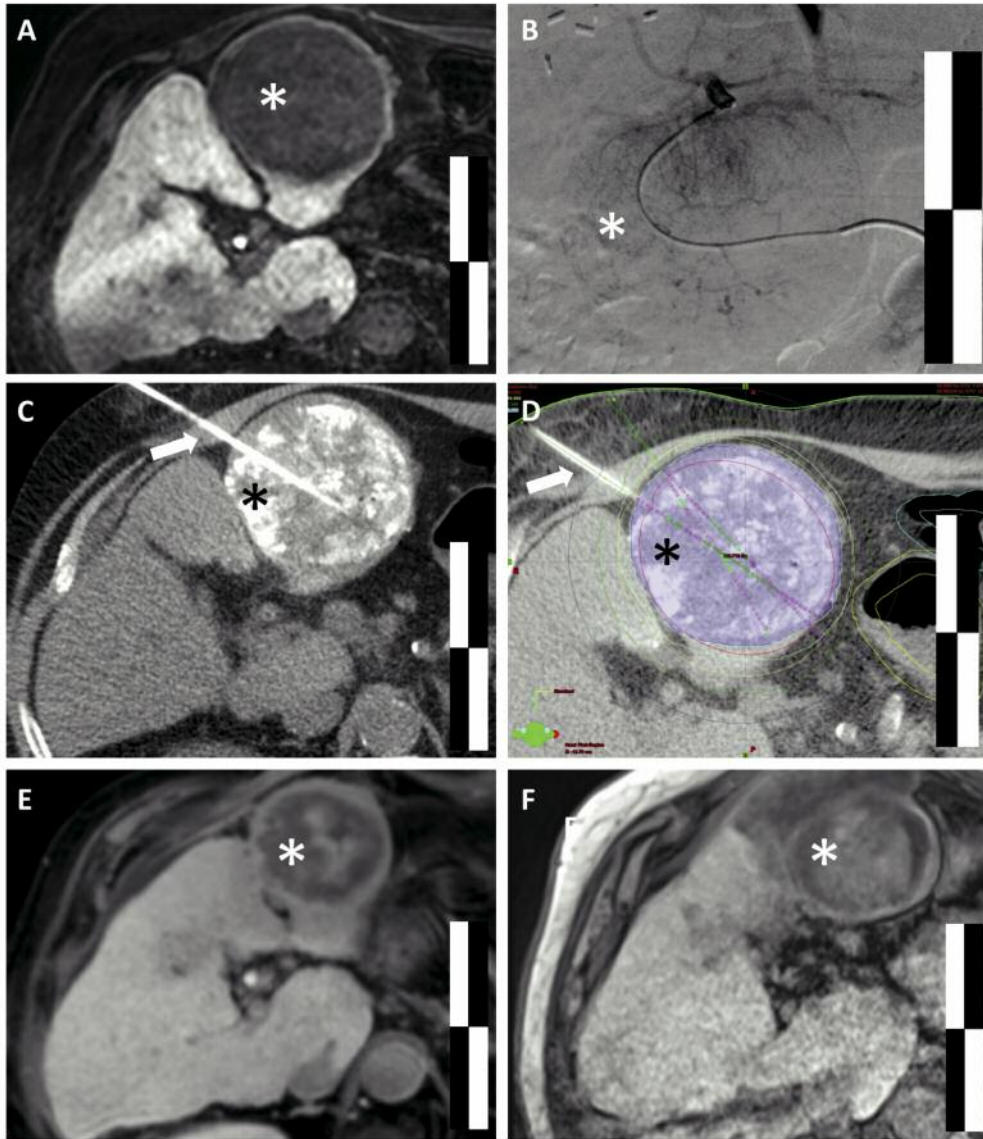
Treatment process of a patient treated with Chemoembolization and CT-HDRBT. (A) Shows the pretreatment MRI imaging of the tumor. (B) Shows the hypervascularisation of the tumor on DSA before Chemoembolization. The good delineation of the tumor on native CT imaging due to the Lipiodol deposition is shown in (C). (D) Depicts the dose planning of the CT-HDRBT following the placement of the catheters. (E) and (F) show the shrinkage of the tumor on follow-up imaging after 9 and 20 months, respectively. *Indicates the tumor while the arrows point to the CT-HDRBT catheters. Scale bars: 5/10 cm.
